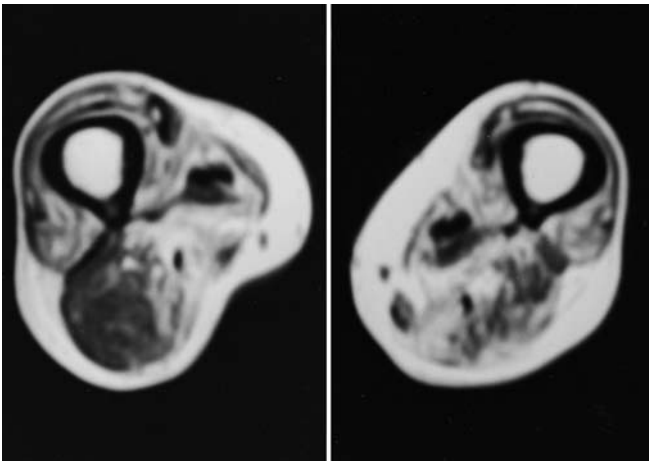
T1-weighted magnetic resonance image reveals marbled brightness of the bilateral quadriceps, demonstrating muscle atrophy and replacement by fatty tissue
